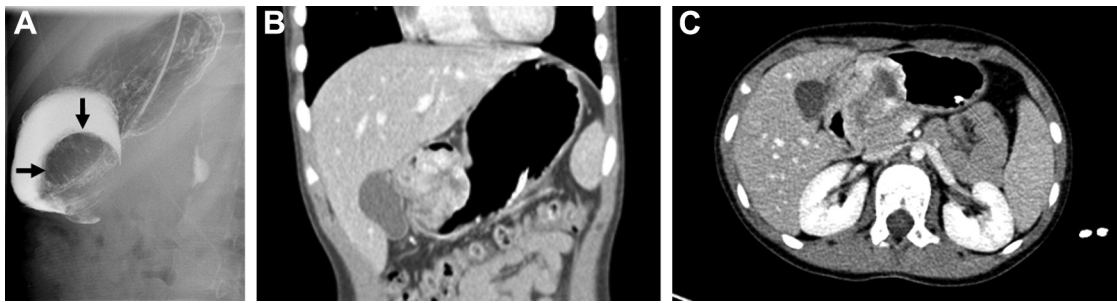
Radiographic findings. UGI series demonstrated a large mass with a broad base attachment to the posterior wall of the distal stomach resulting in high-grade partial gastric outlet obstruction (A), the edge of the tumor is highlighted with arrows. The tumor was better delineated on CT scan (B, coronal view; C, axial view).
